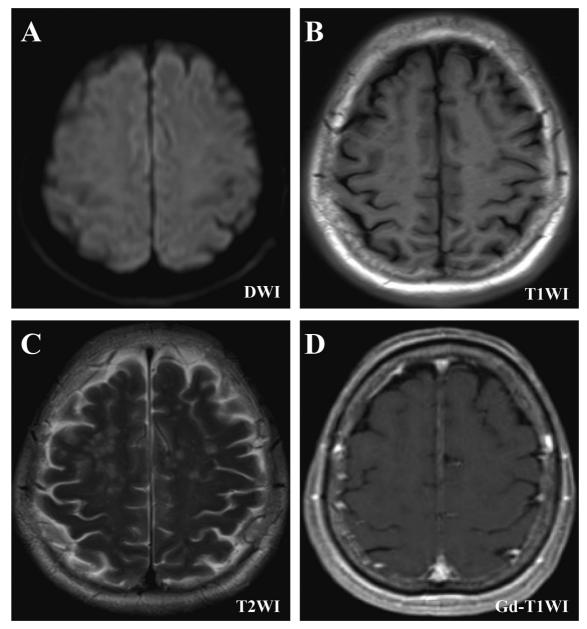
Pre-treatment brain magnetic resonance imaging (MRI) in Case 2. Brain MRI showed only nonspecific hyperintense lesions in the white matter on T2-weighted imaging (T2WI) (C). Diffusion-weighted imaging (DWI) showed no high-intensity lesions (A). T1-weighted imaging (T1WI) showed no abnormalities (B), and gadolinium (Gd)-enhanced T1WI showed no enhancement in white matter lesions (D).
